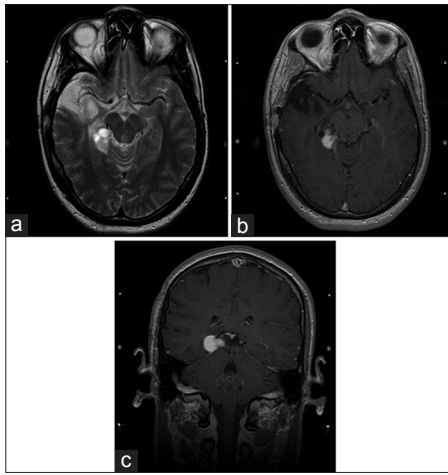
(a-c) 2005 Stereotactic axial T2, axial and coronal CET MR images demonstrate the increase in DNT size and contrast enhancement just prior to Gamma Knife treatment
